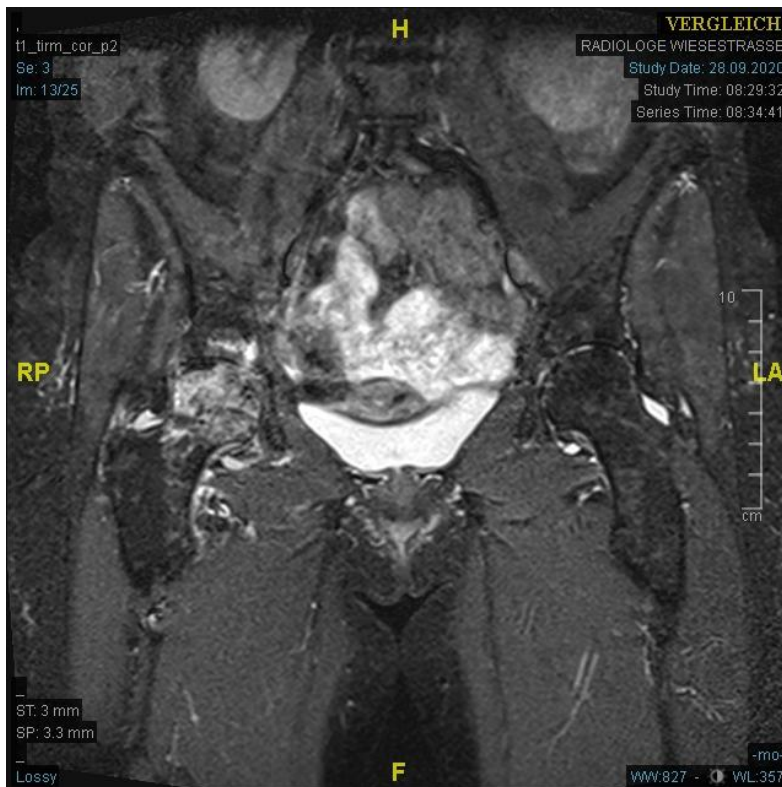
MRI-examination showing destruction of the right hip joint.
